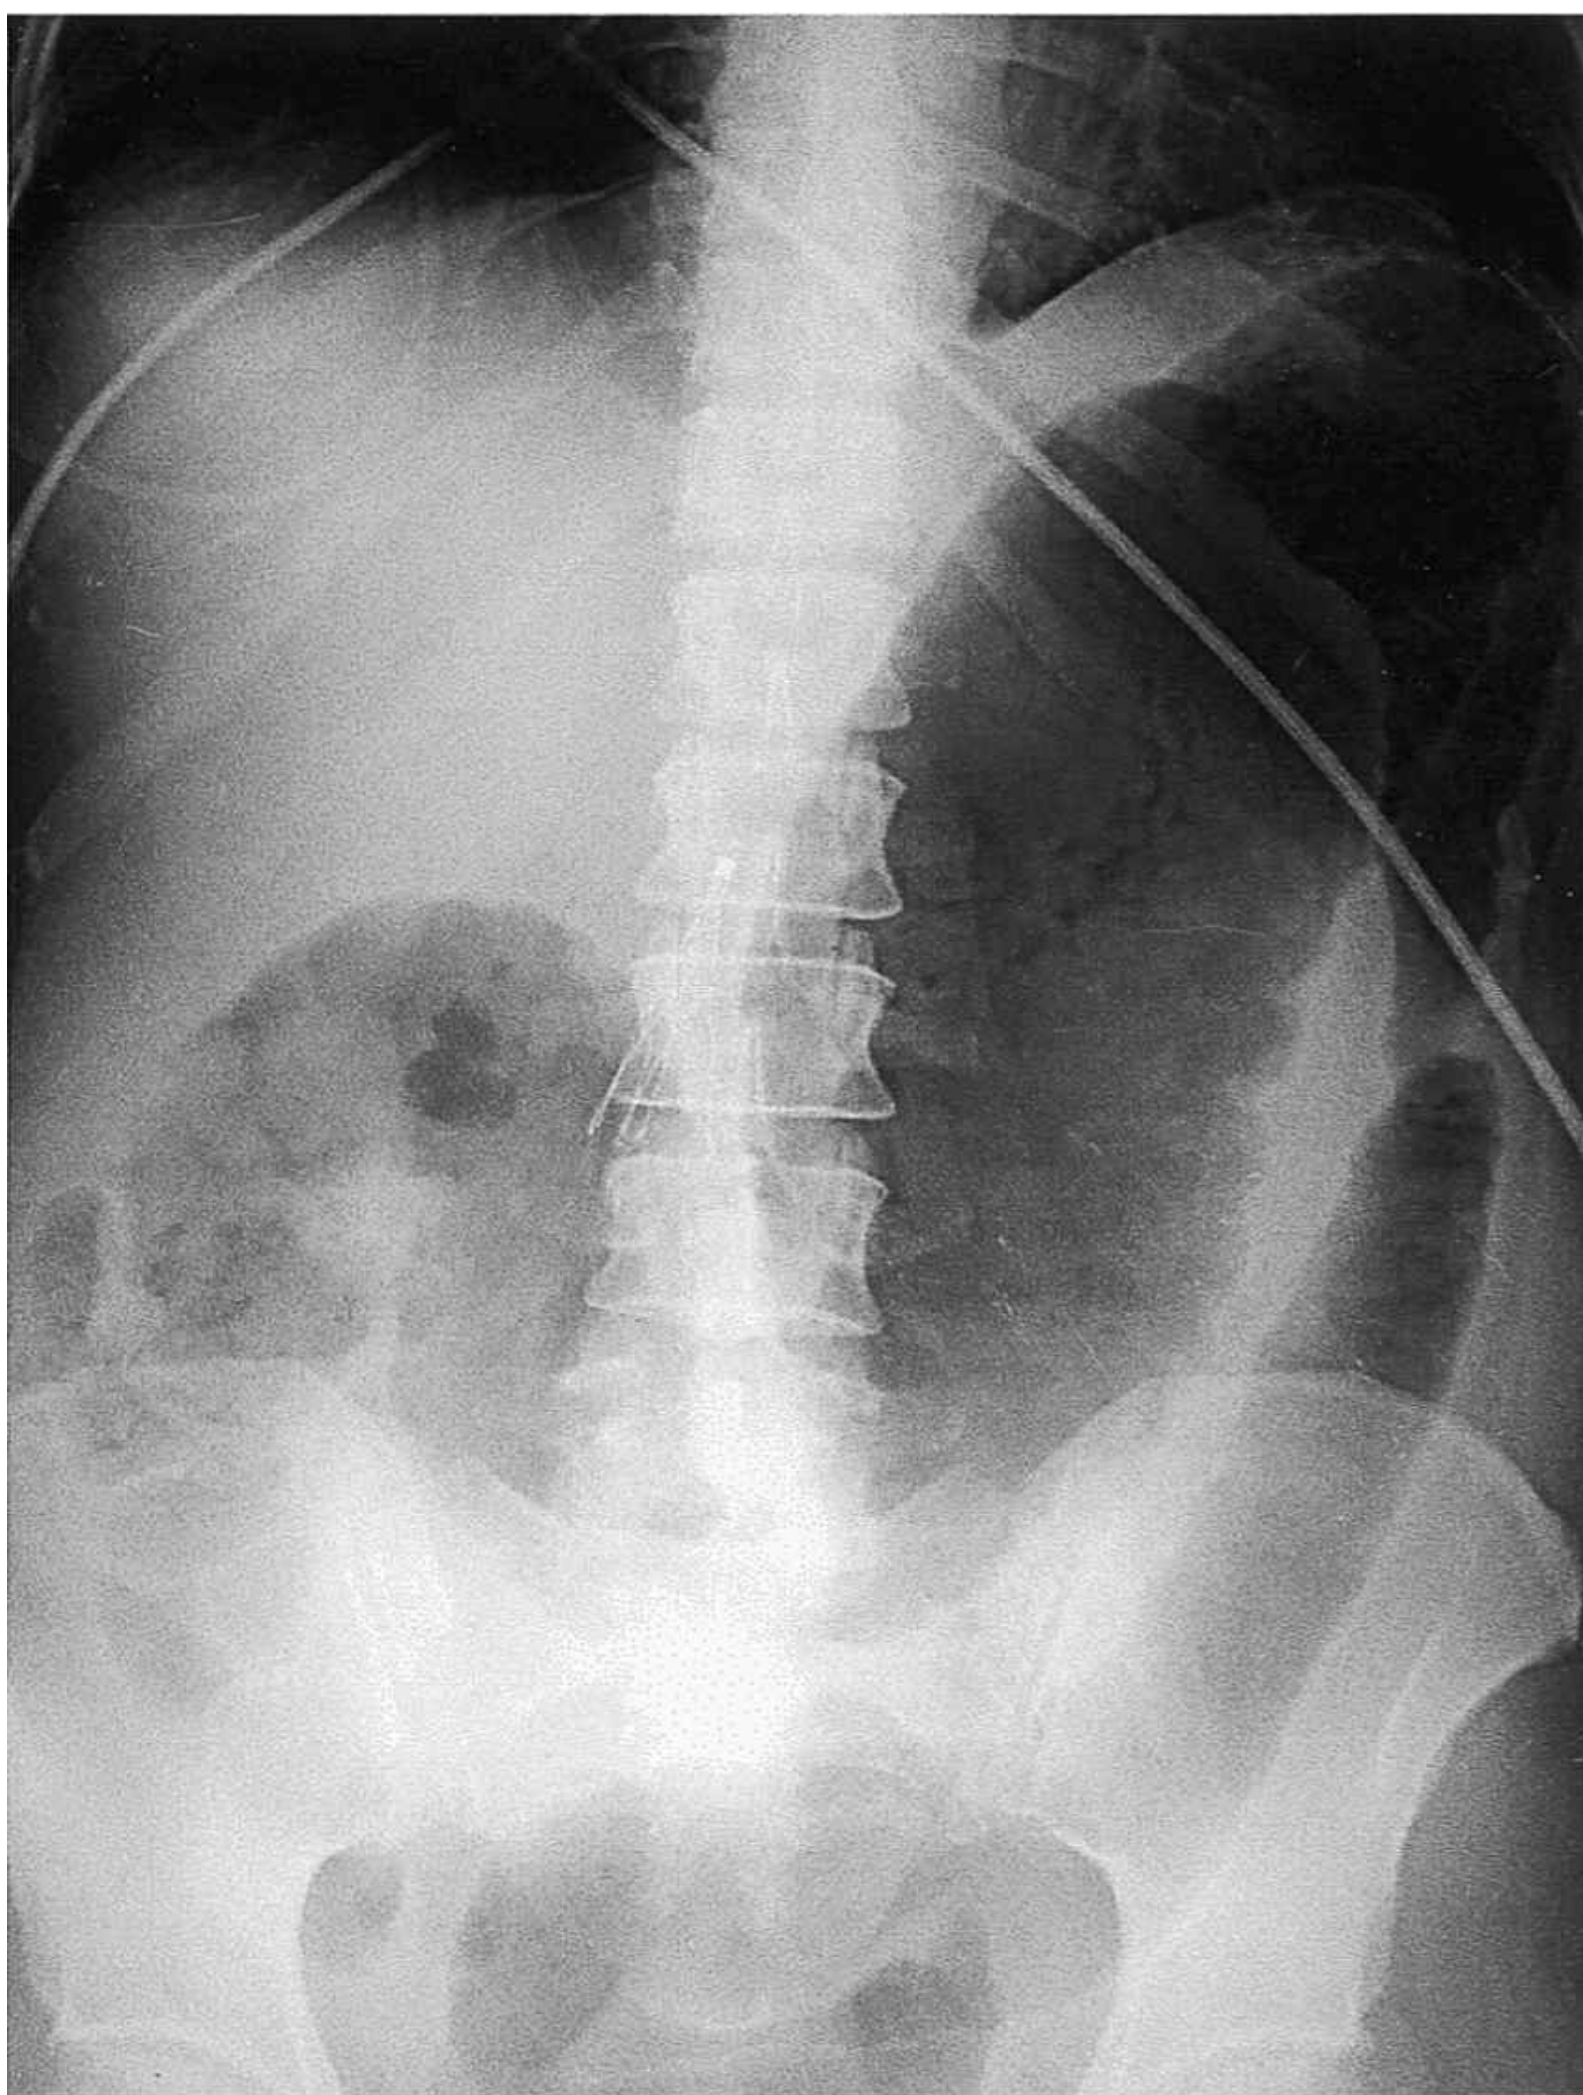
Toxic megacolon with perforation. Supine radiograph demonstrates marked mucosal nodularity and thickening of the transverse colon. (Reproduced, with permission, from Bongard FS, et al. *Current Diagnosis & Treatment: Critical Care*. 3rd ed. New York: McGraw-Hill; 2008.)
